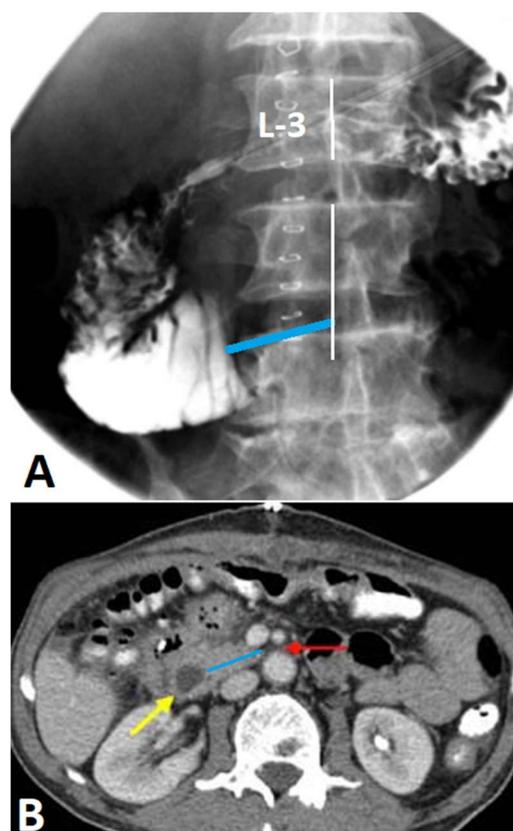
A 70-year-old man with a duodenal ulcer. On the 7th day after laparotomy and pyloroplasty, large residual volumes of stomach and vomiting appeared. Based on X-ray and CT studies, the SMAS was diagnosed. (From the article Chan DK. et al [11]. With the permission of the authors). Aortomesenteric distance (red arrow) is projected into the center of the vertebra. Duodenum - yellow arrow. A) The distance from the beginning of the narrowing
